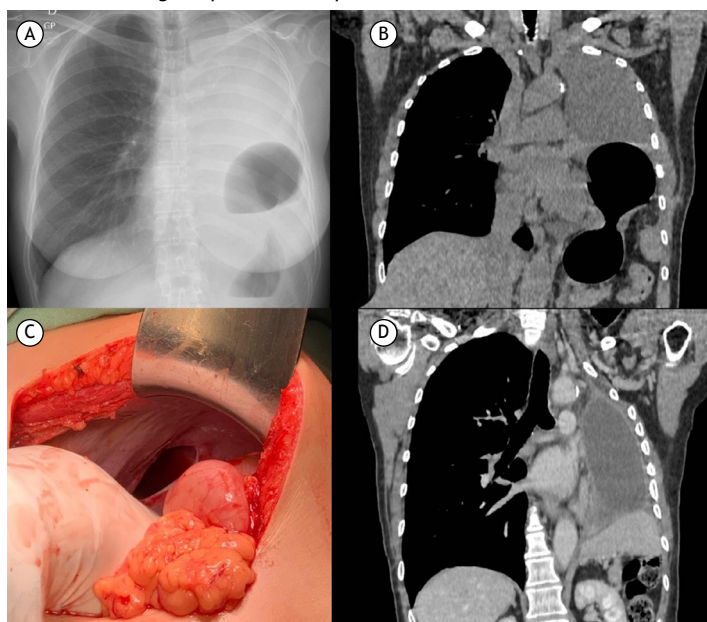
In A, a chest x-ray (frontal) performed on admission. In B., chest CT showing diaphragmatic hernia with gastric contents and pleural fluid filling the post-pneumonectomy cavity. In C, intraoperative image with identification of the diaphragmatic defect. In D, a control chest CT scan two years after diaphragmatic correction showing no herniation.
